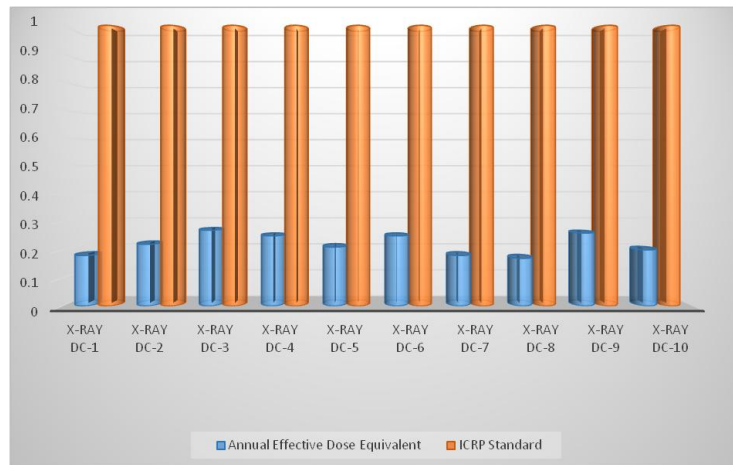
Annual Effective Dose Equivalent of the sampled X-ray diagnostic centers with ICRP, 2003
